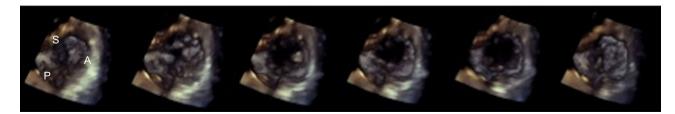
Right ventricular view of the tricuspid valve through the cardiac cycle by 3-dimensional transesophageal echocardiography. A, anterior leaflet; P, posterior leaflet; S, septal leaflet.
